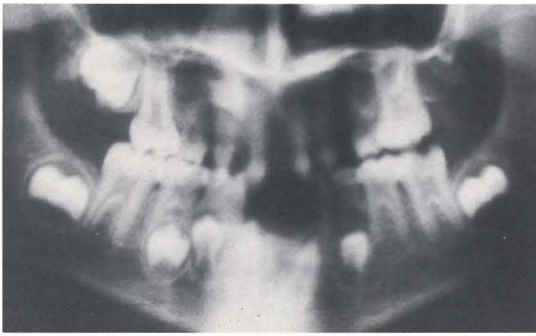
Panoramic and periapical radiographs show absence of teeth and double tooth in the maxillary left primary second molar region.
